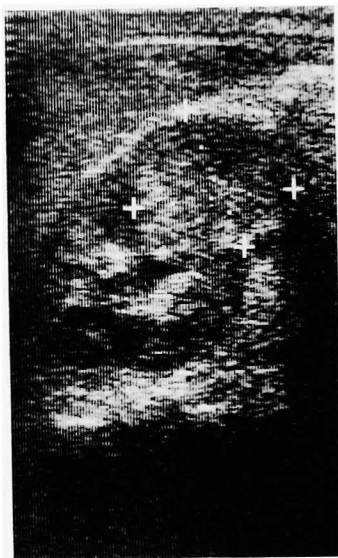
Renal sonography: An ill-defined echogenic mass was found in the right kidney.
